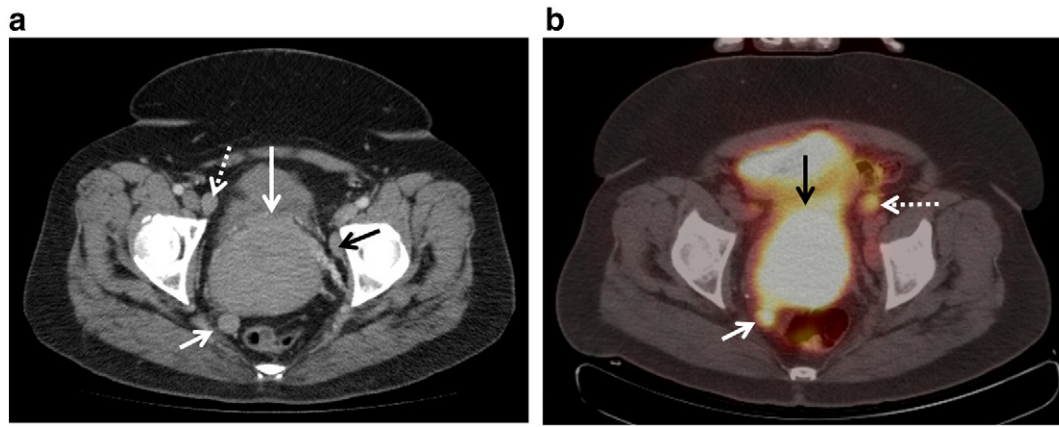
(a) Contrast-enhanced computed tomography (CT) of a 54-year-old woman who presented with vaginal bleeding with remote history of subtotal hysterectomy with evidence of a large tumour of the residual cervix on pelvic examination. It shows an 8-cm cervical mass with smooth borders (solid long white arrow), a left external iliac lymph node (LN) (black arrow), a right external iliac LN (dashed white arrow), and a right internal iliac LN (solid short white arrow). (b) Positron emission tomography-CT scan showing increased metabolic activity in cervical mass (black arrow), a right internal iliac LN (solid white arrow) and a left external iliac lymph node (LN) (dashed white arrow).
